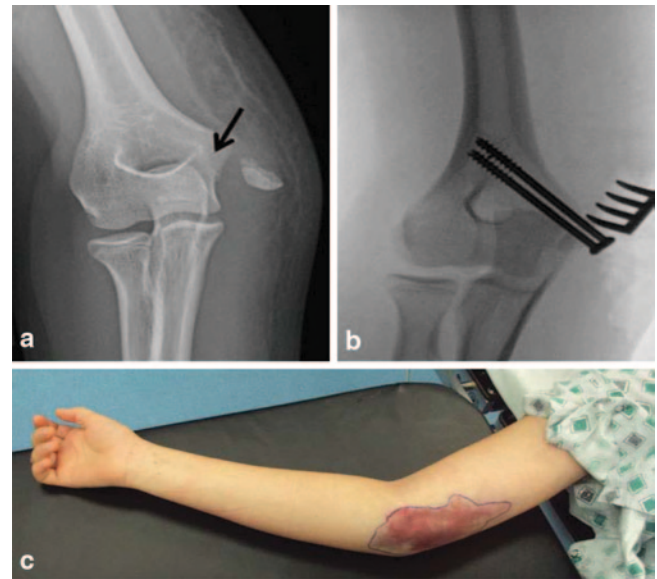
Acute medial epicondyle fracture. A 13-year-old boy who fell while playing basketball. Radiograph shows the fracture displacement (a). The clinical picture shows the large bruising on the medial aspect of the elbow (b). Due to the amount of fracture displacement, surgery was done for open reduction and internal fixation (c)
